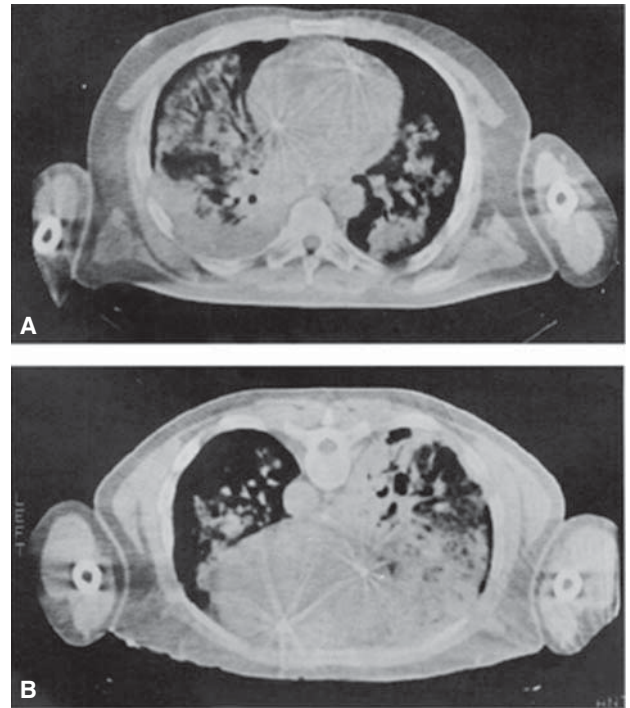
A representative CT scan image in supine (A) and in prone (B) positions. Note the typical redistribution of lung densities. Images taken 10 minutes apart, and at end-expiration apnea, with 10 cm H_2O PEEP. (Used, with permission, from Gattinoni et al.⁶)
